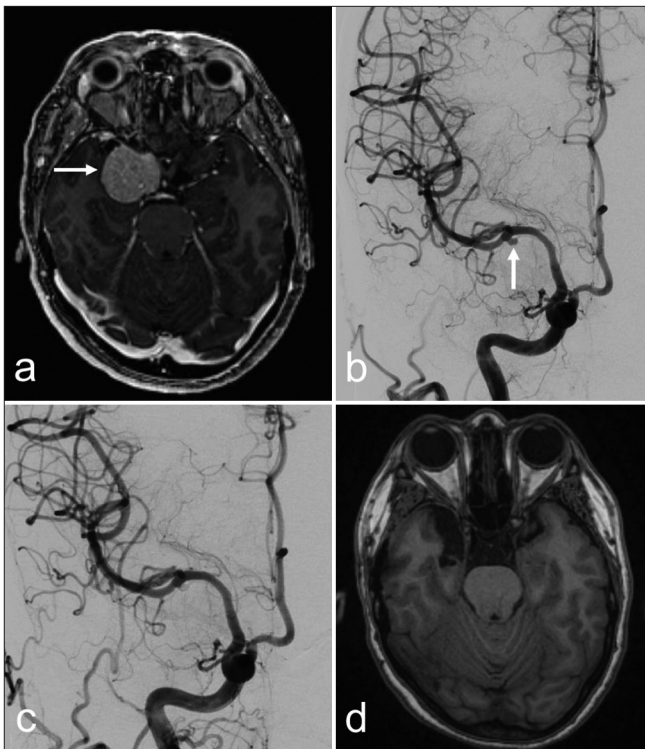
Axial (a) magnetic resonance imaging (MRI) view depicting a right sphenoid wing meningioma (white arrow) with extension to the cavernous sinus. (b) Digital subtraction angiography view showing an aneurysm at the right middle cerebral artery bifurcation (white arrow). Postoperative angiogram (c) showing resolution of the aneurysm, and (d) MRI showing complete resection of the brain lesion.
